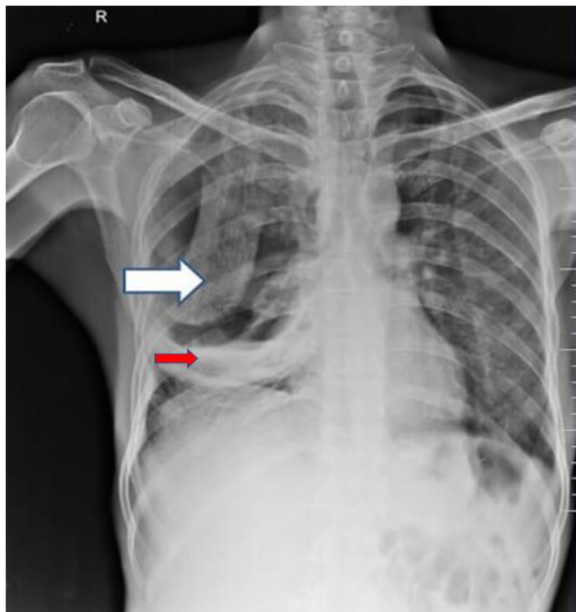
Plain radiograph of chest posteroanterior view shows loculated right hydropneumothorax (red arrow) with collapsed lung (white arrow)
